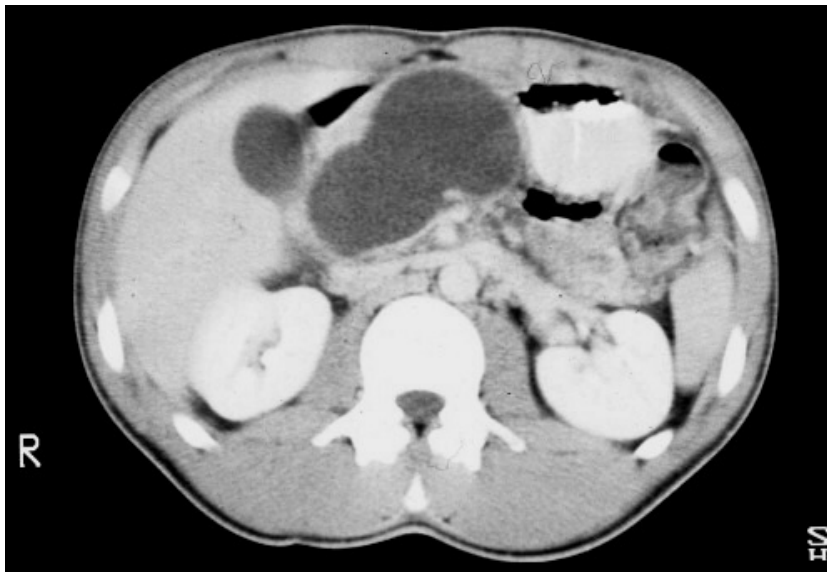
CT appearance of a pseudocyst
